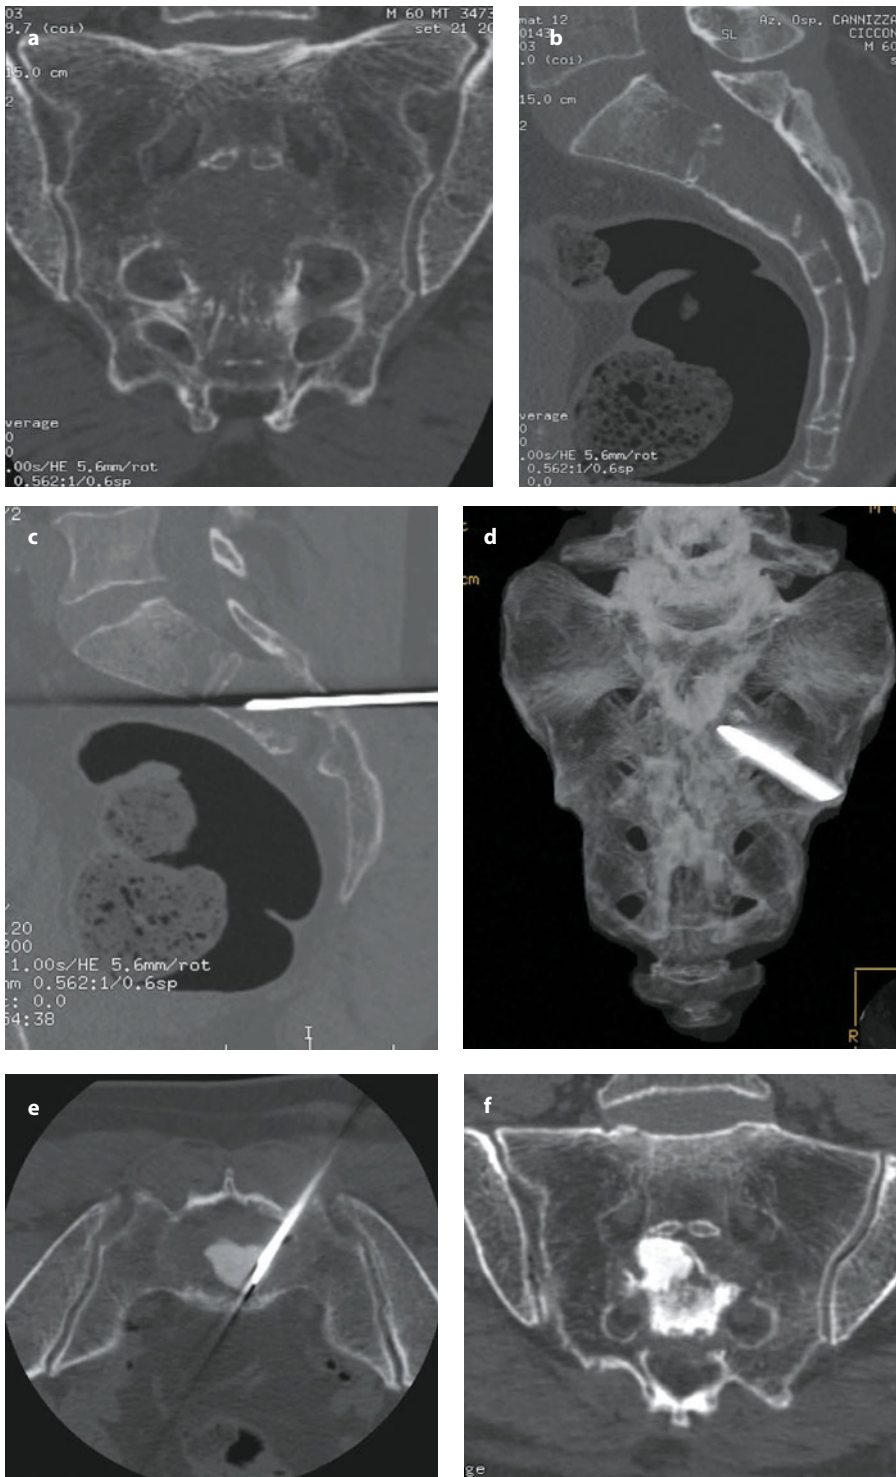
Osteoconductive augmentation of the sacrum. A large sacral defect into the S2 body is observed in a patient previously affected by multiple myeloma (a and b). A 11-G needle is placed into the sacrum (c and d) and a small amount of osteoconductive material introduced using a X-ray–CT-guided technique (e). After 45 days, regrowth of new bone into the sacrum is observed (f)
